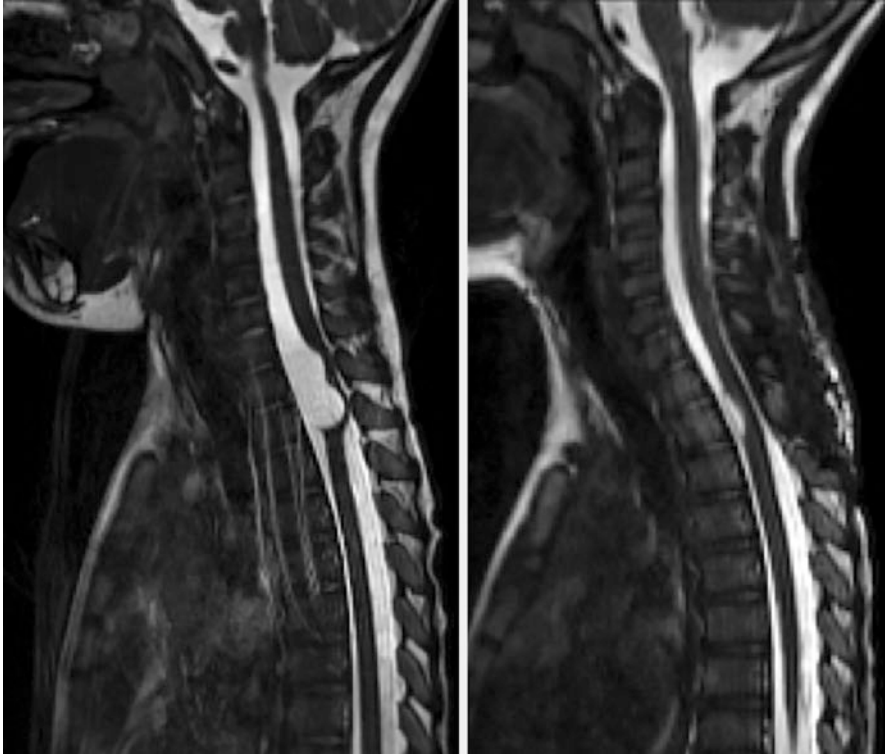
Left: Sagittal CISS MR image of the cervical spine in a 3 years old child showing a ventrally located intradural arachnoid cyst. Right: Sagittal MR image 6 months after successful microsurgical fenestration through a 3-level laminoplasty
